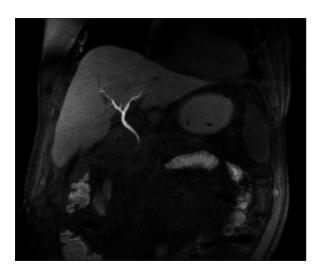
T1-weighted contrast-enhanced cholangiography. Maximum Intensity Projection (MIP) reconstructed T1-weighted image, in the hepatobiliary phase shows the biliary tree, hyperintense because of the excretion of the contrast agent.
